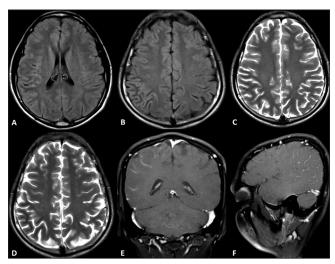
(a-d) Axial T2 and FLAIR MR images showing focal subcortical T2 hypointensity in the right parietal lobe, with corresponding sulcal FLAIR hyperintensity (e and f) Corresponding region leptomeningeal contrast enhancement seen
